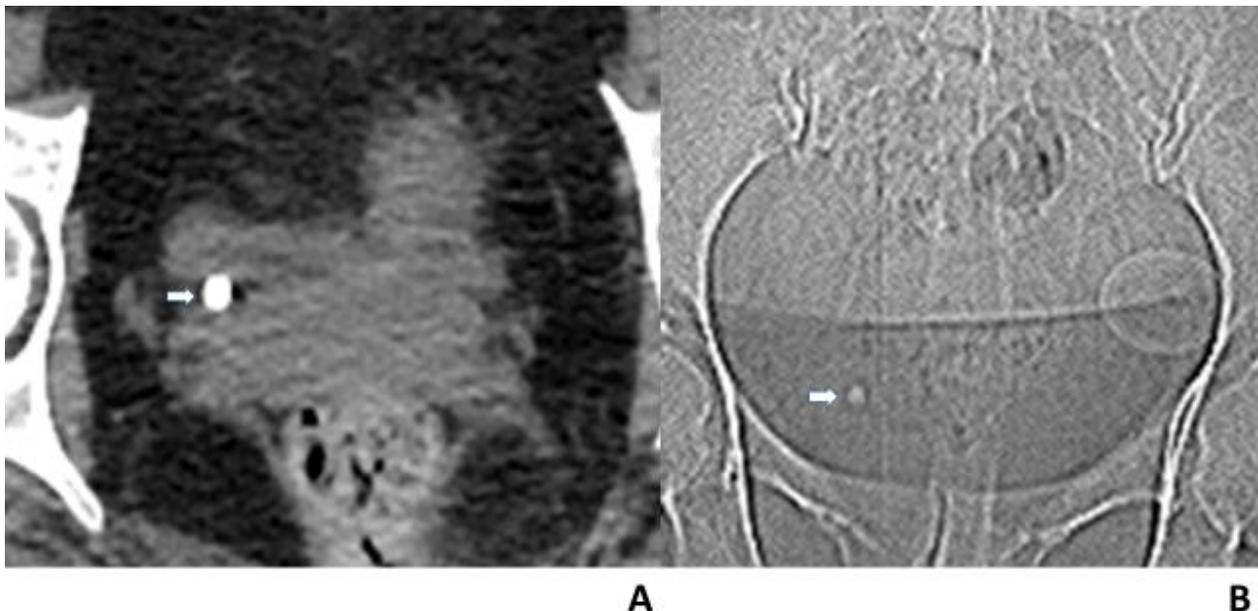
A 35-year-old woman with a right ureteral stone. A, Axial CT scan shows a ureteral stone at right UVJ (arrow) measuring 6 mm. B, CT scout radiograph shows a right ureteral stone.
